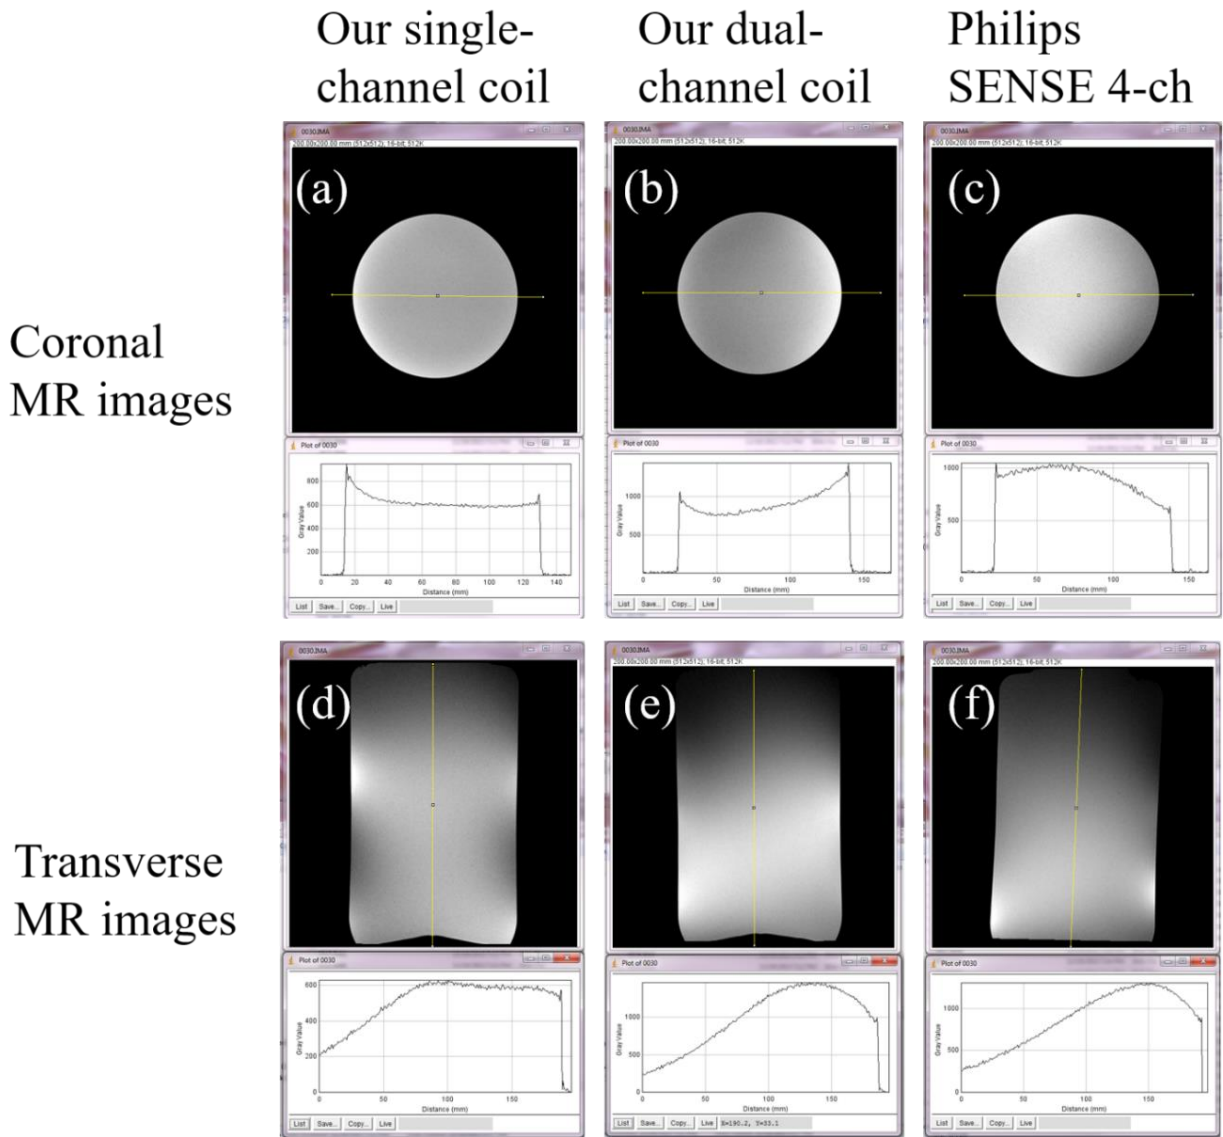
Coronal 2D MR images with the intensity plots along the solid yellow lines from (a) our single-channel solenoid coil, (b) our dual-channel breast coil, and (c) Philips SENSE 4-channel breast coil. Transverse 2D MR images with the intensity plots along the solid yellow lines from (d) our single-channel solenoid coil, (e) our dual-channel breast coil, and (f) Philips SENSE 4-channel breast coil.
